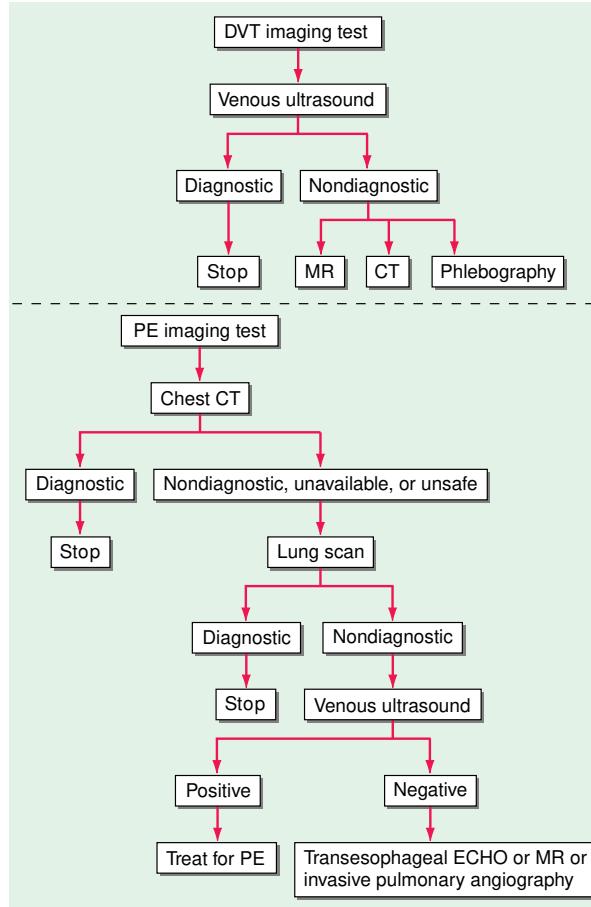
Imaging tests to diagnose deep-venous thrombosis (DVT) and pulmonary embolism (PE). ECHO, echocardiography; MR, magnetic resonance.
